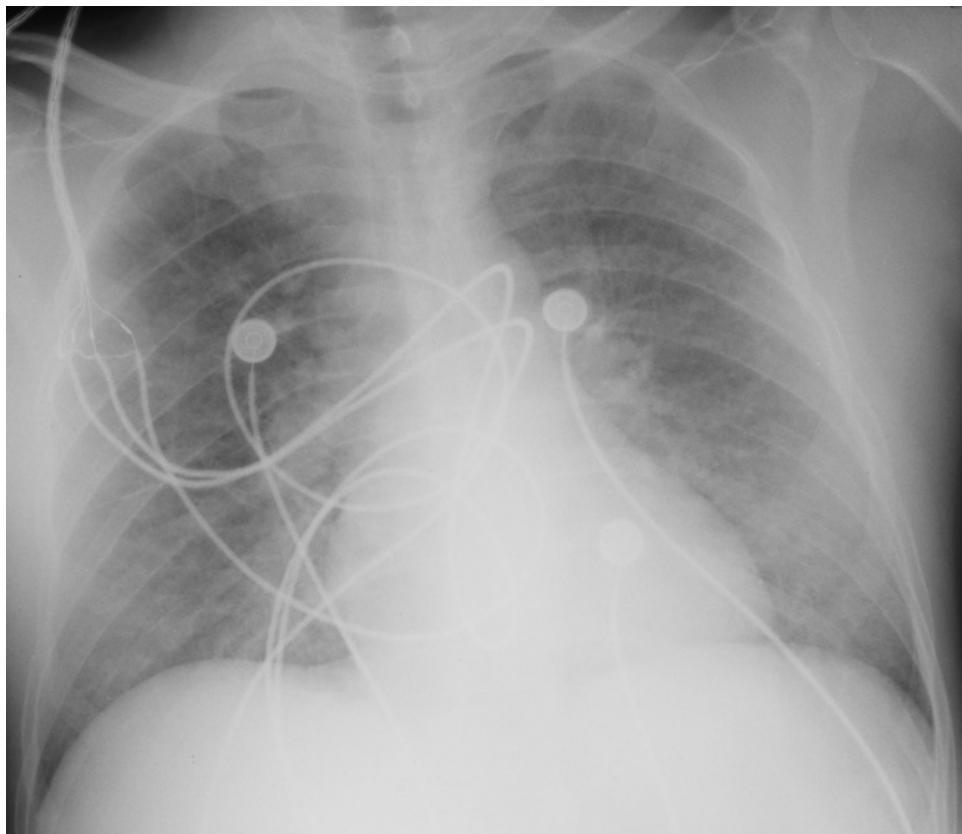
Cardiogenic shock following an initial massive myocardial infarction. The patient is a 48-year-old man with acute coronary syndrome. Findings include a severe alveolar pulmonary edema with only a moderately enlarged heart. Vascular structures are blurred. No effusion. The patient died 3 hours after the radiograph was obtained.
